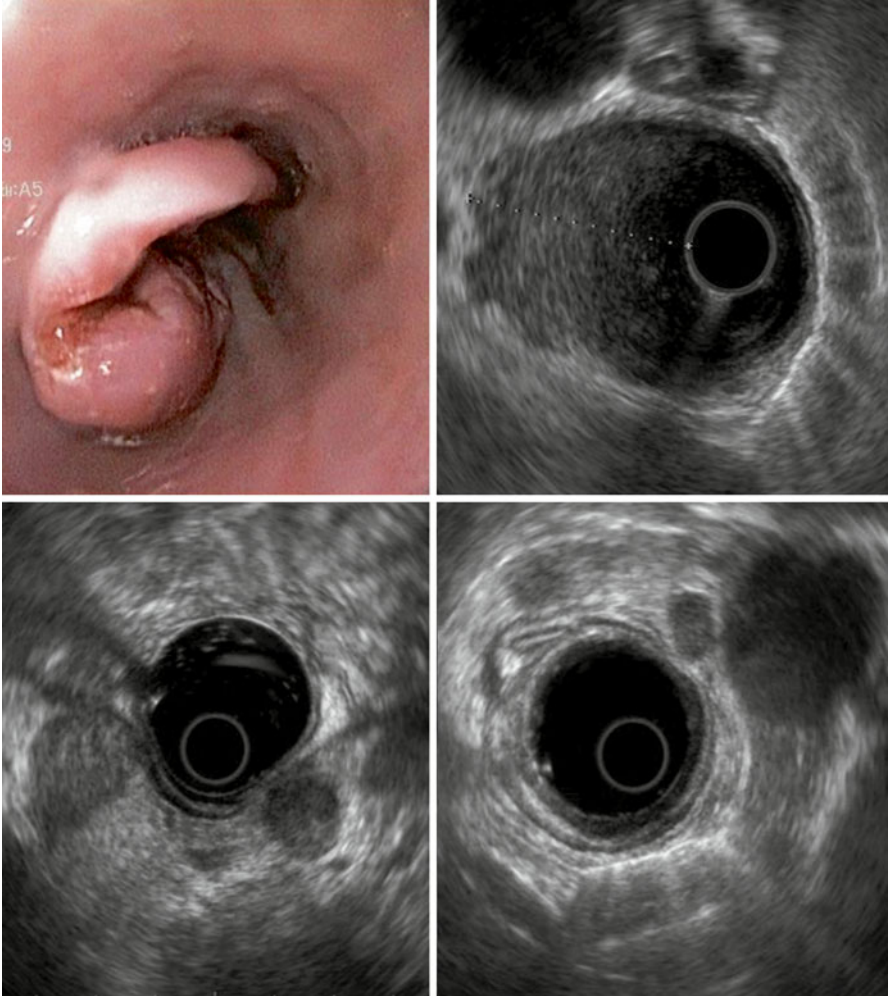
Endoscopy and endoscopic ultrasound. Distal esophageal adenocarcinoma
